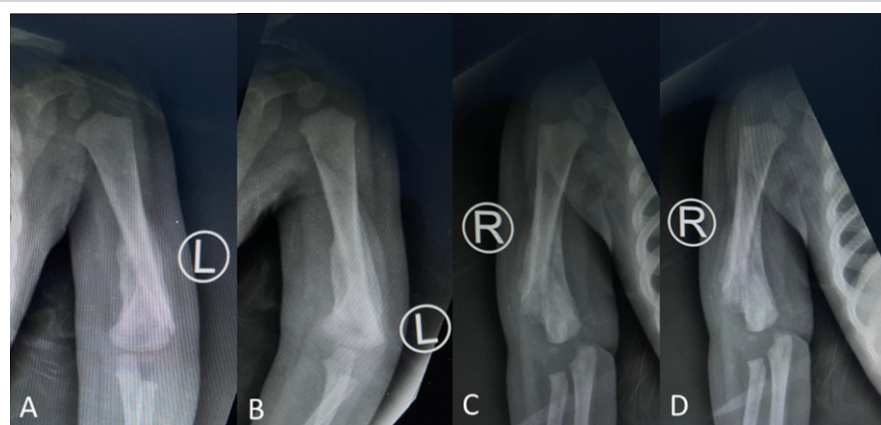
(a and b) Anteroposterior view and lateral view of left elbow showing 3 weeks post-trauma radiograph with abundant callous and good union. (c and d) Anteroposterior view and lateral view of right elbow showing 3 weeks post-trauma radiograph with abundant callous and good union.
